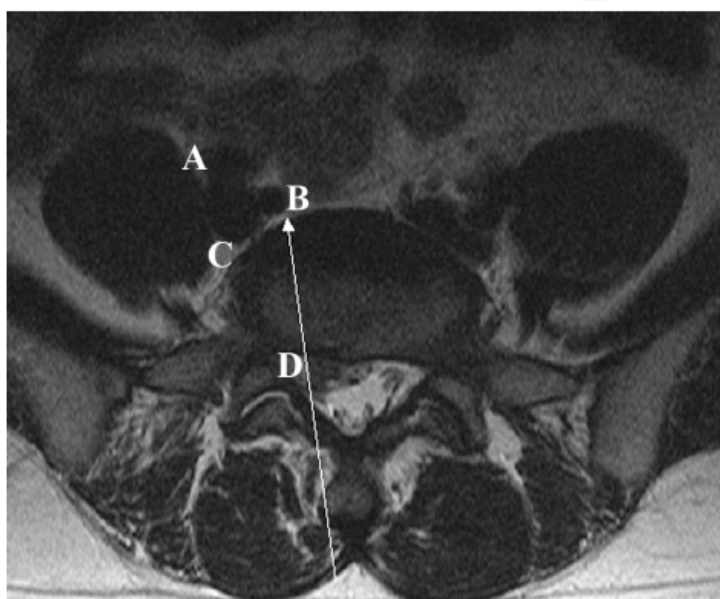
Preoperative axial MRI at the L5-S1 level. White arrow indicates the direction of the carbon dioxide laser beam. A, External iliac artery. B, Internal iliac artery. C, Common iliac vein. D, Herniated disc fragment.
